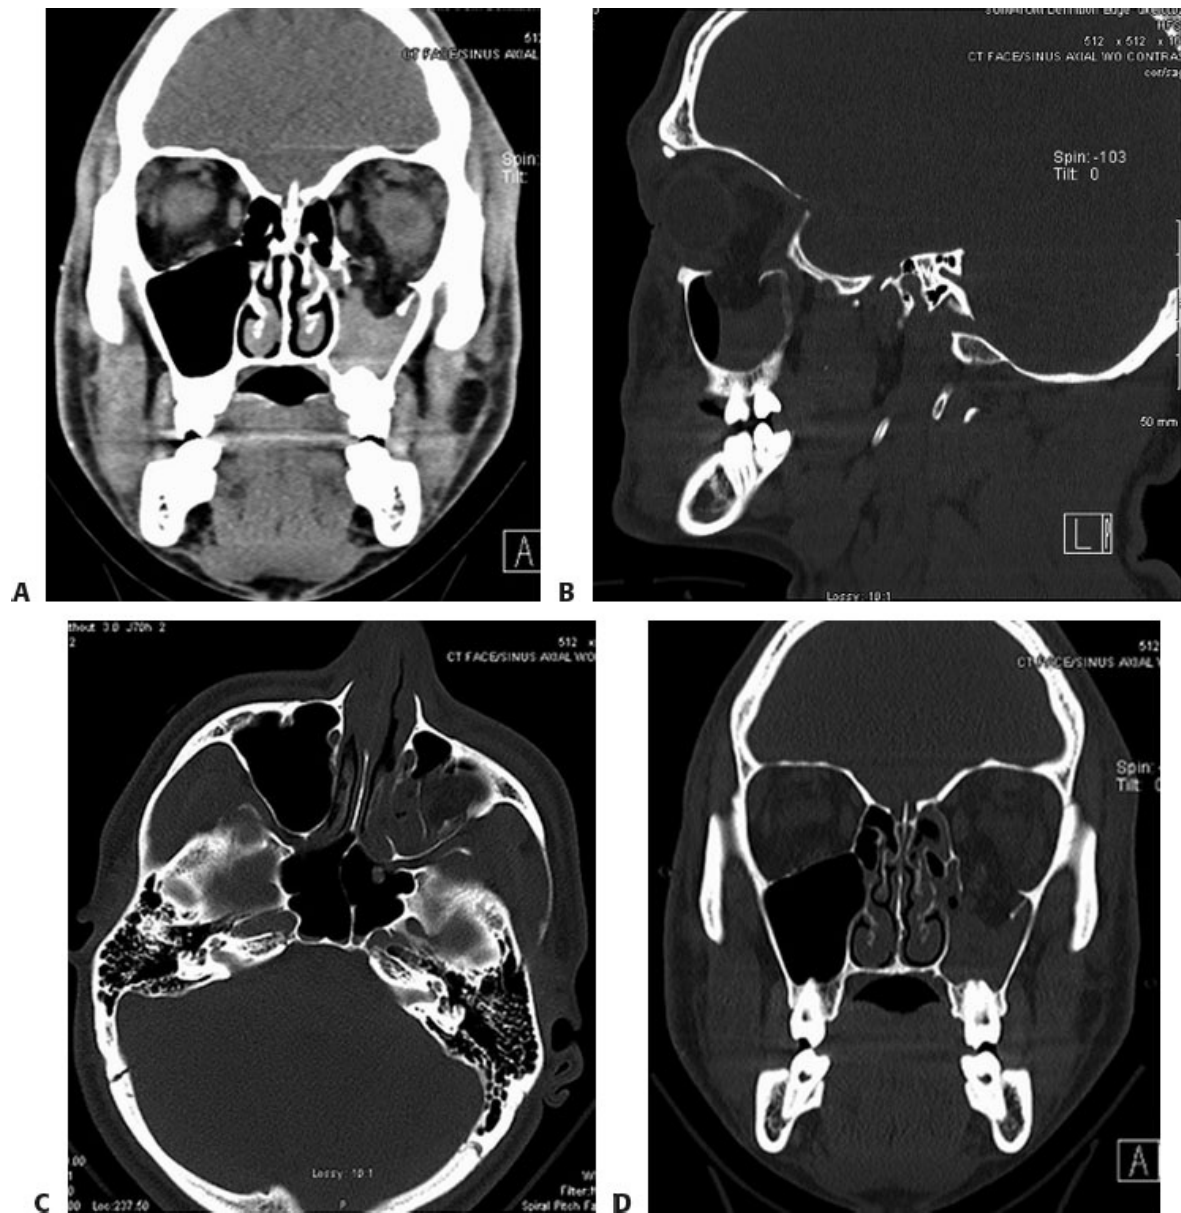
• A. Coronal CT scan image showing left orbital floor blow-out including opacification of maxillary sinus. B. Sagittal CT image of orbital blow-out fracture. C. Axial CT image showing fracture of left orbital floor.
